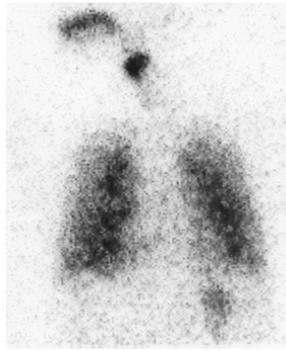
Anterior gamma scintigraphic image of subject immediately after inhalation of radiolabelled BDP, showing even distribution of the ^{99m}Tc radiolabel within the airways.
